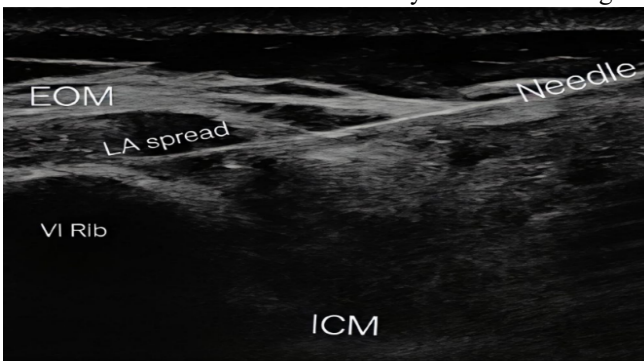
Ultrasound picture of EOI plane block showing spread of local anaesthetic between external oblique and intercostal muscle at the level of 6th rib
